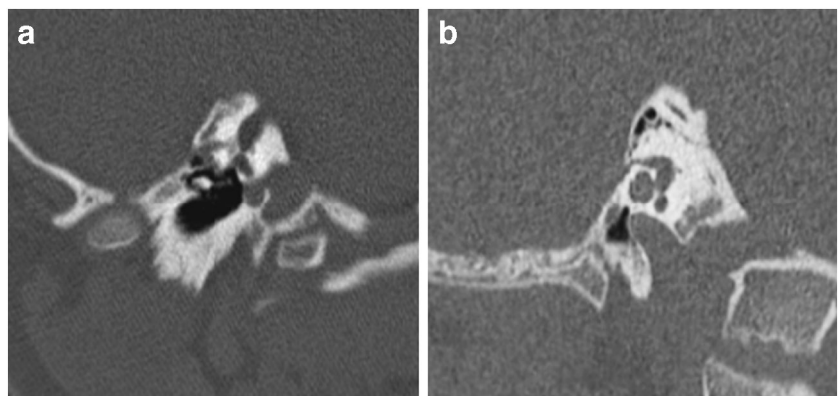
Petrous ridge towering in a 15-year-old girl with achondroplasia. a Coronal CT reconstruction shows the upward tilting of the petrous bone and vertical rotation of internal acoustic canals (*arrows*). b Coronal
